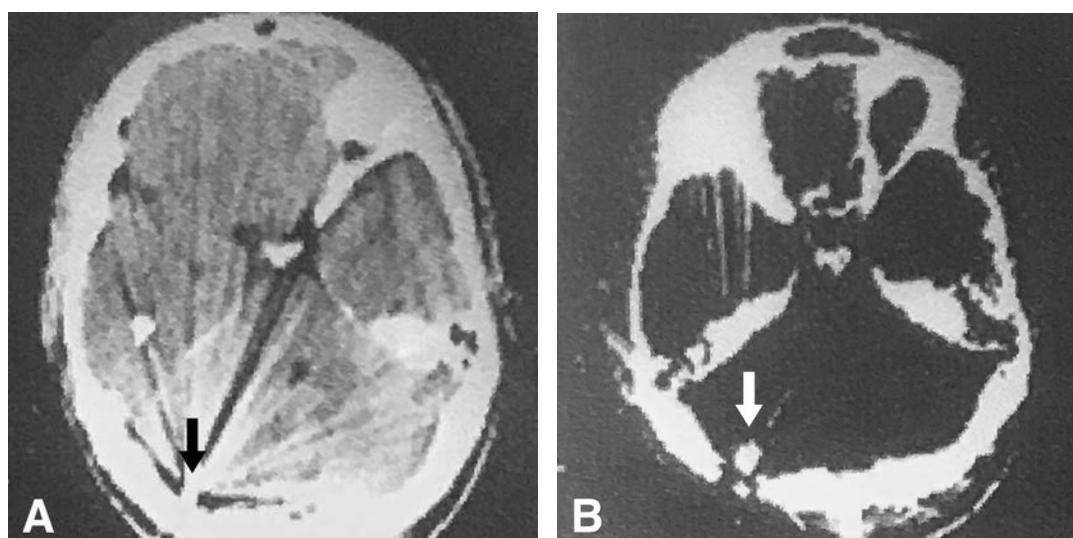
Initial postoperative computed tomography showing the retained bullet located in the *posterior fossa* near *foramen magnum*: A) Axial brain scan with many artefacts (arrow pointing to the bullet); B) Axial hard structures scan (arrow pointing to the bullet).
